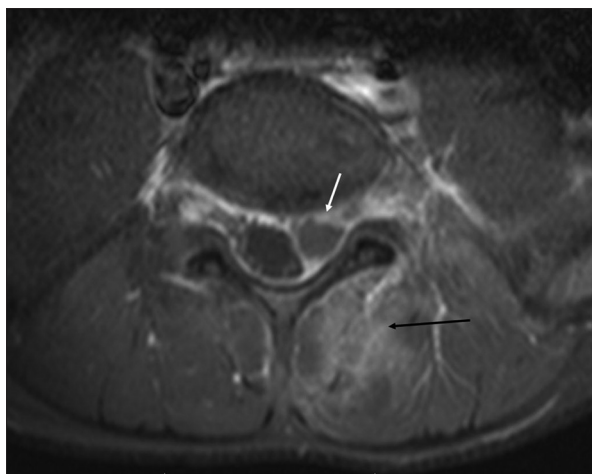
Axial, T1-weighted MR images with Gadolinium injection showing well-defined epidural fluid collection lateralized to the left displacing dural sac to the right side with enhancing wall (white arrow). Please note also enhancement of left paraspinal muscles (black arrow)
